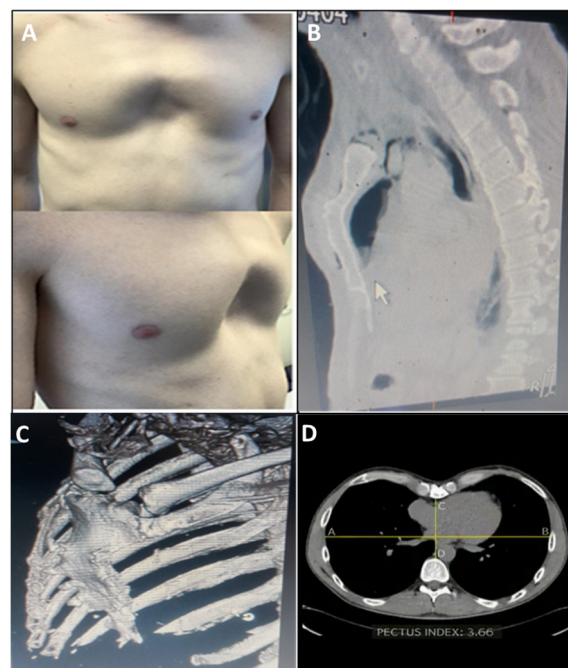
Preoperative pictures showing sternal deformity (AP and RT oblique view), B: Preoperative CT chest (Sagittal view) showing sternal deformity (pectus Excavatum), C: Preoperative 3D CT chest showing sternal deformity (Pectus Excavatum), D: Preoperative CT chest (Axial view) with HI 3.66.
